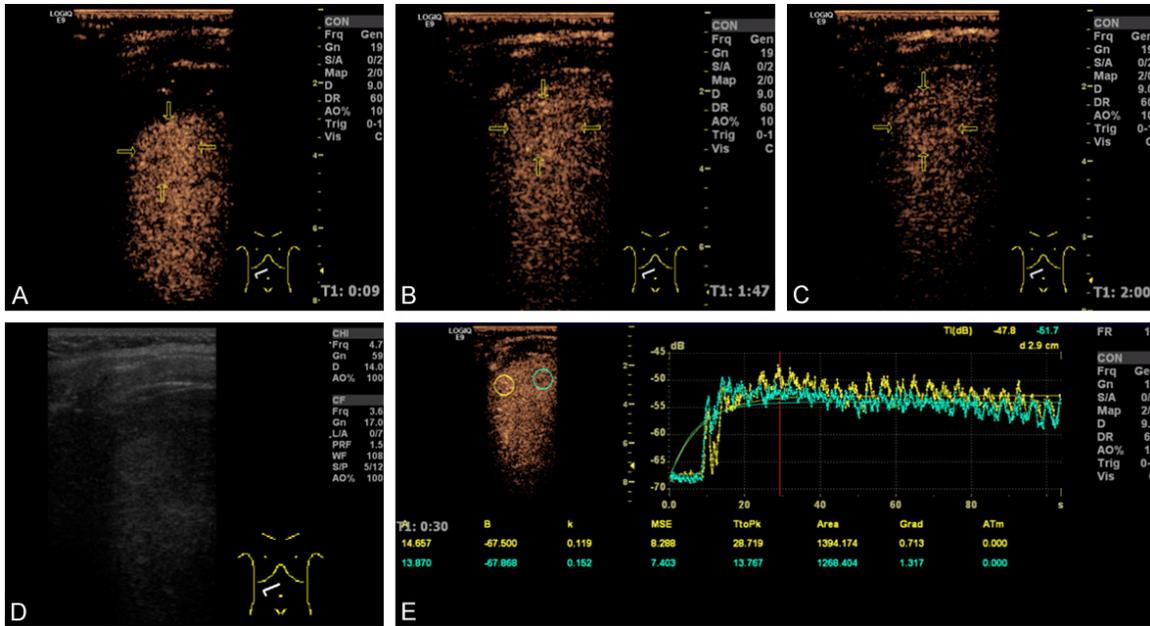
CEUS and TIC analysis for FNH. A: CEUS image shows high enhancement on 9 s in the arterial phase; B: CEUS image shows high enhancement on 107 s in the portal phase; C: CEUS image shows equal enhancement on 125 s in the late phase; D: Gray-scale ultrasound shows a hyperechoic mass within the right lobe of the liver; E: FNH time-intensity curve is “flat”.
